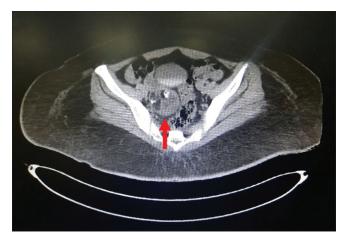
Abdominal computed tomography scan result: a well-defined, heterogeneously enhancing, ovoid, mixed solid, and cystic mass in the right adnexa (arrow) measuring 5.6 cm × 5.2 cm × 4.1 cm, with coarse calcific and fat-attenuating components detected within the lesion, suggestive of teratoma
